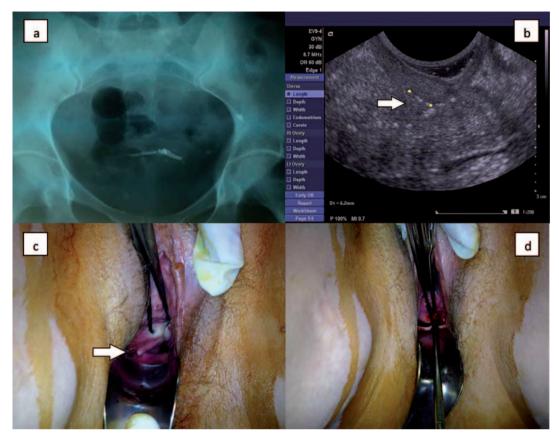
IUD cervical perforation (a - pelvic X-ray before IUD extraction; b - control ultrasound scan of the uterus after IUD extraction with the marked perforation site; c - partial IUD perforation of the isthmico-cervical region distorting the cervix; d-transcervical IUD extraction).
